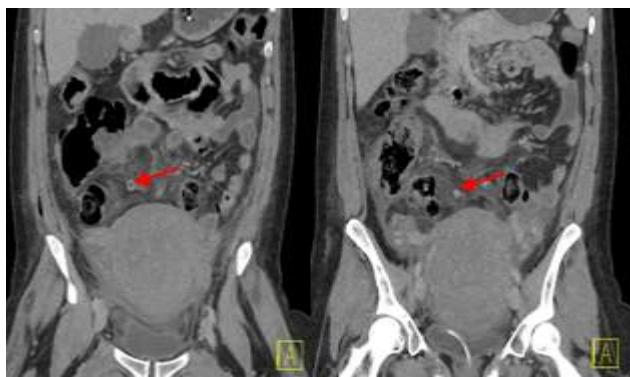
Coronal CT slices demonstrating patient's enlarged, post-partum uterus, appendix (arrow) with faecolith (right) and abdominal free fluid.
